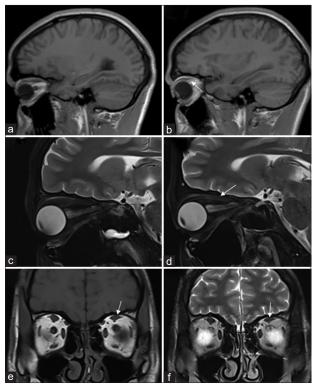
Magnetic resonance imaging images of orbits of a 23-year-old male with chronic progressive external ophthalmoplegia plus: (a), Right orbit, T1W1 contrasted sagittal plane. (b) Left orbit T1W1 contrasted sagittal plane. (c) Right orbit, T2WI FAT SAT, sagittal plane. (d): Left orbit, T2WI, FAT SAT, sagittal plane. (e), T1W1 noncontrasted, coronal plane. (f) T2WI coronal plane. Findings: Asymmetrical thinning and reduced muscle volume of the left superior rectus muscle (white arrows) compared to the right side. Areas of the left superior rectus with increased T2W FAT SAT signal intensity are also noted. No abnormal enhancement was present. Bilateral globes were normal in size. Lens were standard in position. No mass lesion was noted within orbits. Bilateral retina and optic nerves were normal along their course
